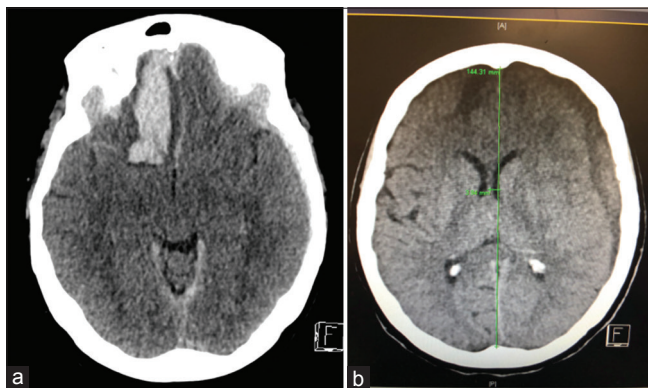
(a) Axial CT scan showing the Fisher Grade 3 aneurysmal subarachnoid hemorrhage. (b) Axial CT showing a left subdural hematoma with 3.94 mm of midline shift
